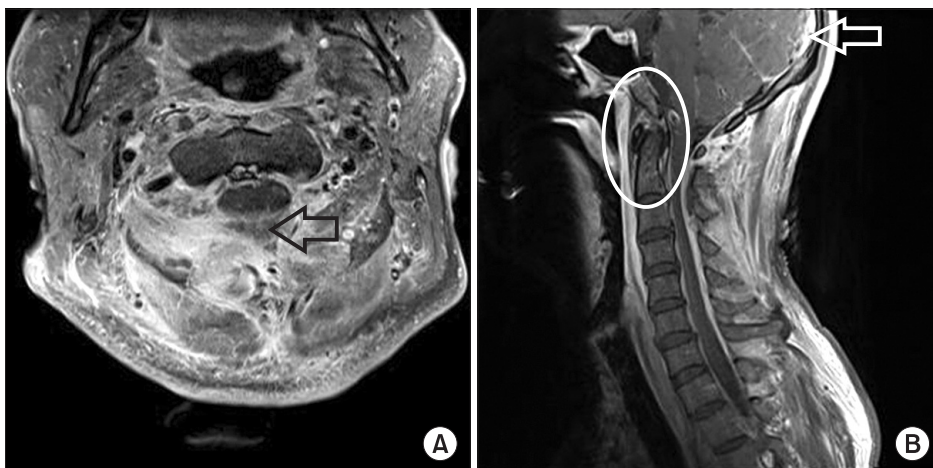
Contrast-enhanced cervical spine magnetic resonance imaging. (A) Posterior epidural abscess; peripheral rim enhancing lesion at the posterior epidural space of cervical spine (C2-3) (arrow). (B) Osteomyelitis; mild enhancement in the clivus and scanned cervical spine (circle), early leptomeningitis; prominent leptomeningeal enhancement (arrow).
